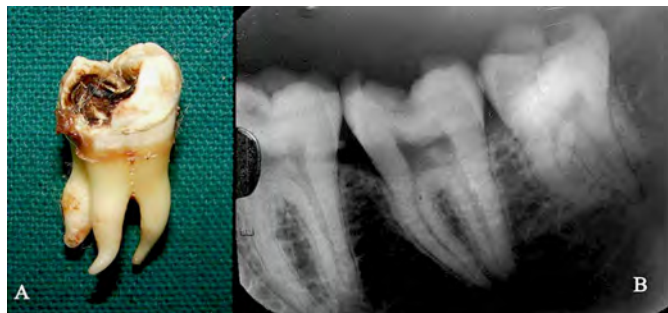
(Left) An extracted mandibular right third molar with a radix paramolaris. (Right) Radiograph of the mandibular left third molar showing only presence of two roots.
